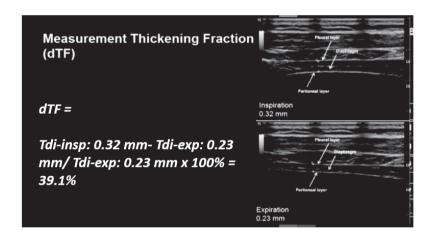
Ultrasound in the zone of apposition and measurement dTF
